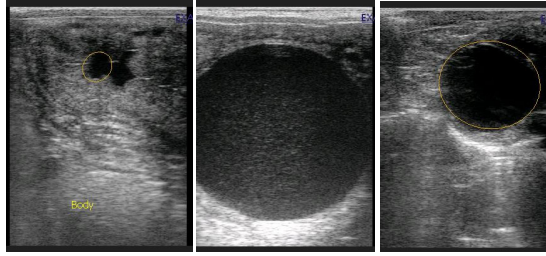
Examples of ultrasonographic images of endometrial cysts
